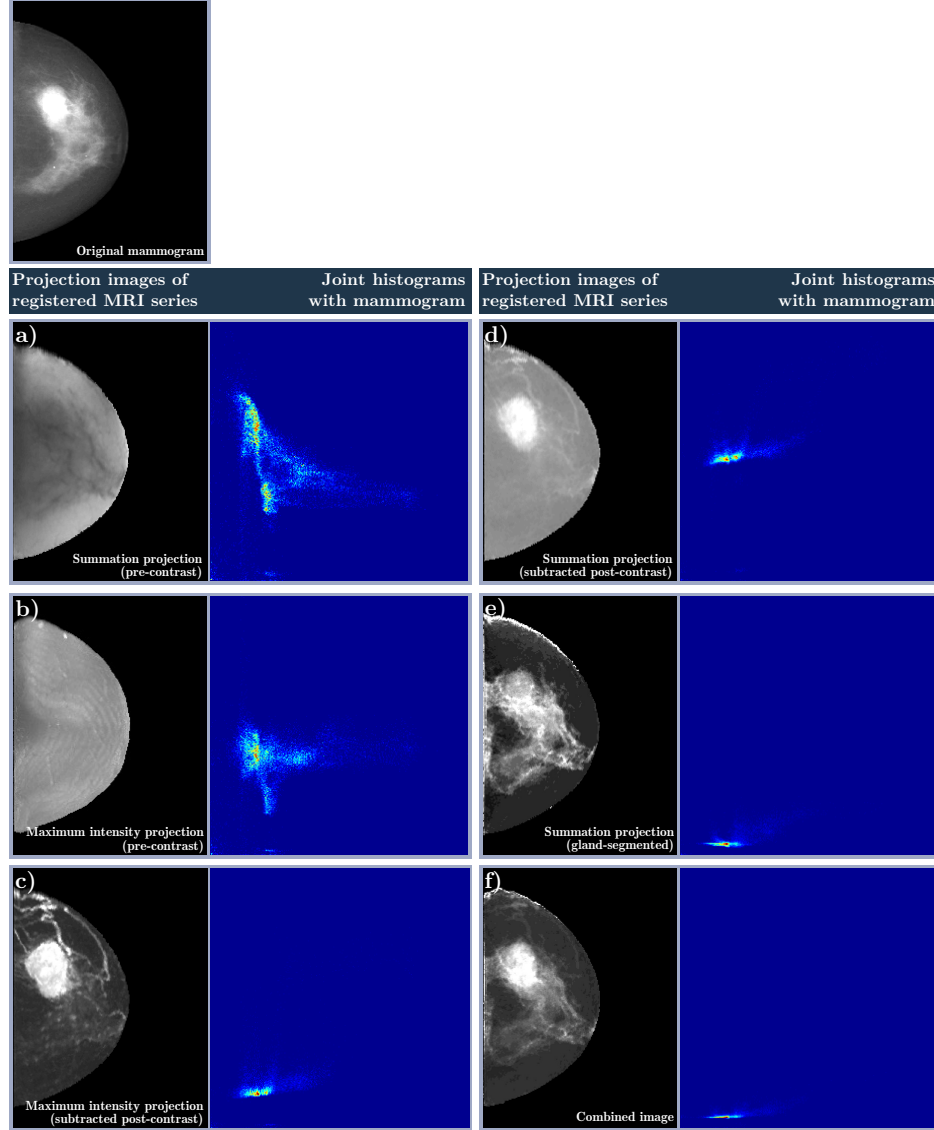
Composition of projection images for image similarity calculation. From a) to d): summation and maximum intensity projections of the pre-contrast series and the subtraction of the pre- and post-contrast series, e): projection of a volume with segmented glandular tissue, f): final combined image. For each projection image, the joint histogram with the X-ray mammogram (top) is given.
